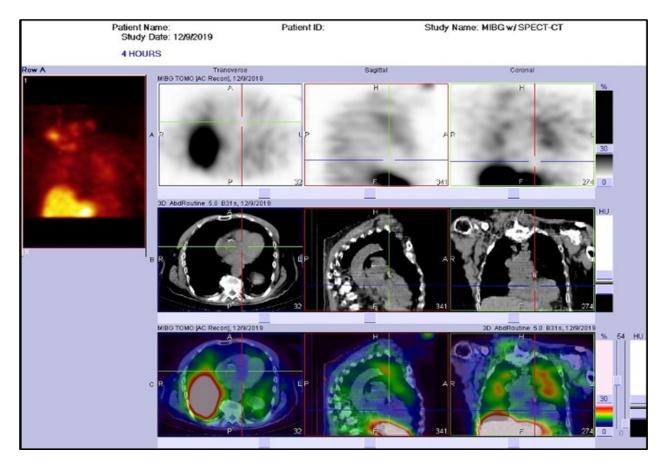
SPECT-CT image of the heart at 4 hours
